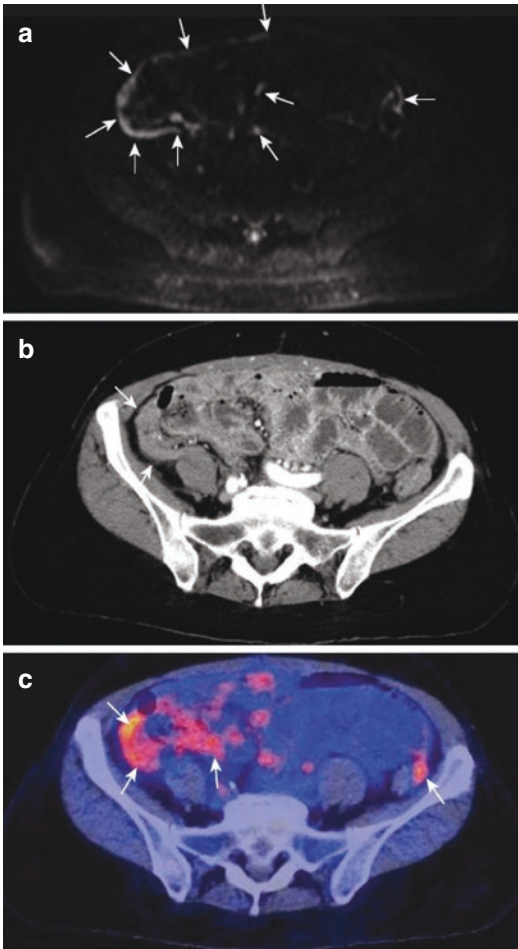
(a–c) Diffusion-weighted imaging (a), CT (b), and ^{18}F -FDG-PET/CT (c) of a 63-year-old female patient with peritoneal metastases originating from ovarian carcinoma: the diffusion-weighted image depicts a laminar involvement of the peritoneal surface extending into the paracolic gutters bilaterally and on the visceral peritoneum of the ileum. The CT depicts a discrete thickening of the peritoneum with increased contrast enhancement. A reliable identification of peritoneal disease is not possible. PET/CT exhibits increased glucose utilization in the paracolic gutters, corresponding with the more pronounced tumor manifestations on the DWI image. The laminar involvement especially of the parietal peritoneum along the abdominal wall and the visceral peritoneum along the small bowel is missed by CT as well as PET/CT and could only be identified by diffusion-weighted imaging in this patient
